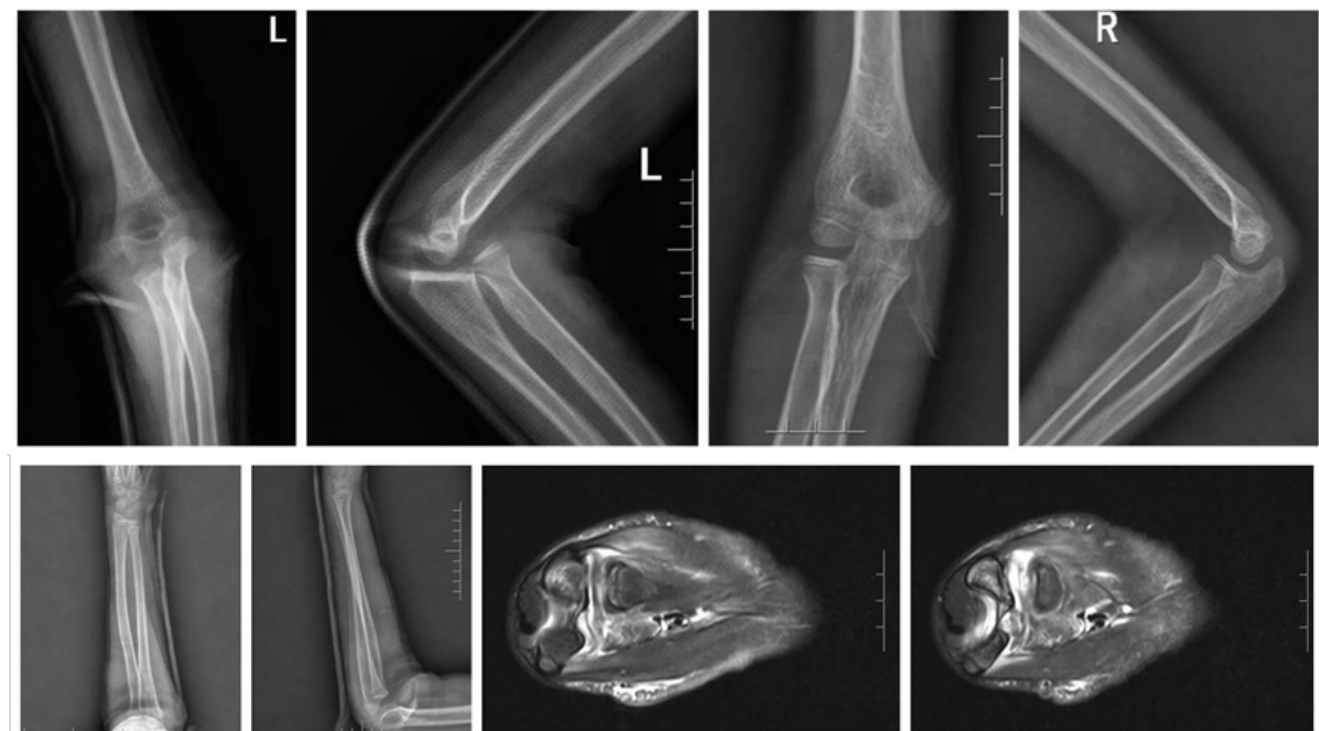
Preoperative radiograph of the left elbow.
